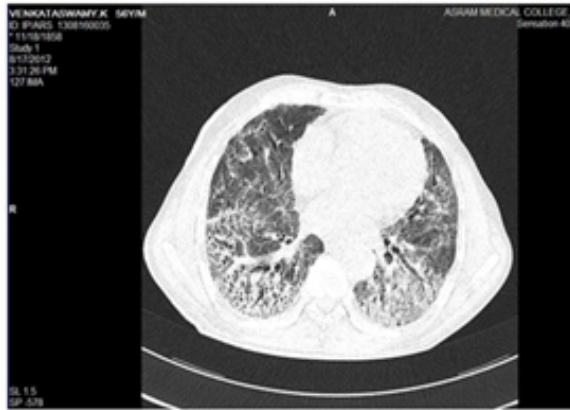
HRCT idiopathic pulmonary fibrosis
